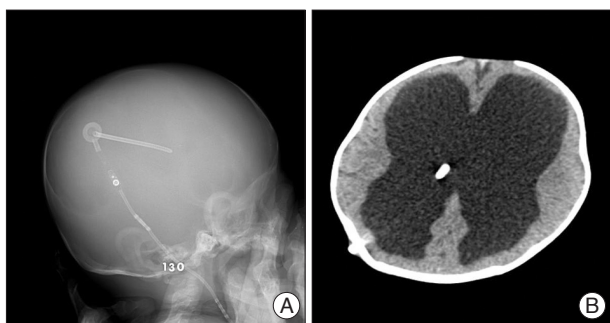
Postoperative operation image (ventriculoperitoneal shunt). A : Plain skull image. B : Computed tomography image.
